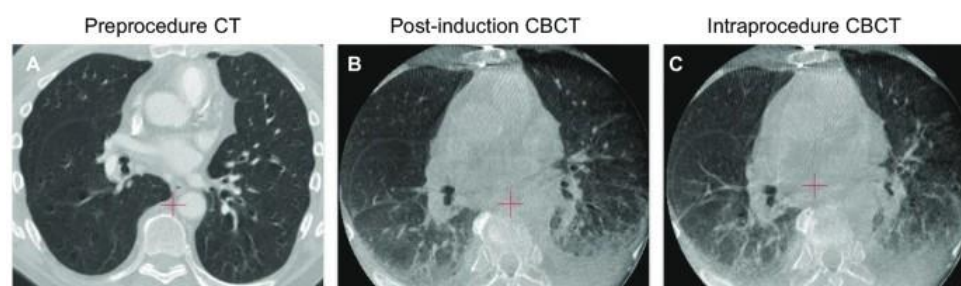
(A) A patient's lungs before anesthesia induction.(B)Atelectasis on the dependent portion of both the lungs after anesthesia induction. Cone-beam CT(CBCT)showing exacerbated atelectasis during the surgery(7)
